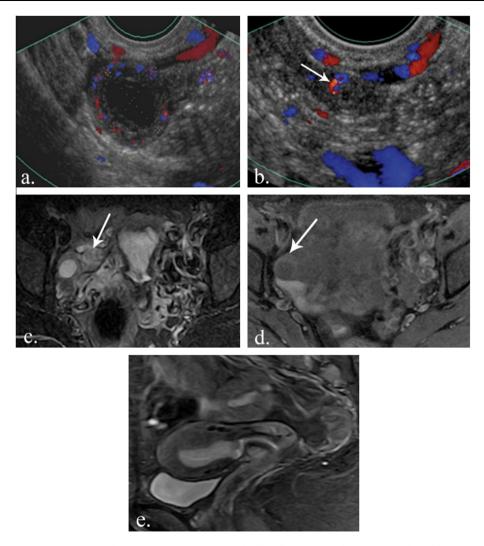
Ectopic pregnancy: a 26 year old patient presented with right iliac fossa pain. The patient had positive pregnancy test yet serum beta HCG was < 1000 mIU/ml. Tranvaginal ultrasound (a & b) revealed a right adnexal cystic lesion showing fine linear internal echoes, with surrounding vascular ring as shown by color Doppler examination, it was interpreted as hemorrhagic corpus luteum cyst. Another suspected small right adnexal mass was seen with internal vascularity (arrow in b) (c & d). Axial STIR and T1 fat sat images revealed a single right adnexal heterogeneous soft tissue shadow (arrow on c) with a well defined cystic component seen in its lateral aspect that shows minimal hemorrhagic changes apparent on T1 fat sat image (arrow on d). (e) Sagittal STIR revealed thickening of the endometrium (decidual reaction), so it was diagnosed by MRI as ectopic pregnancy that was proven latter by laparoscopy.
